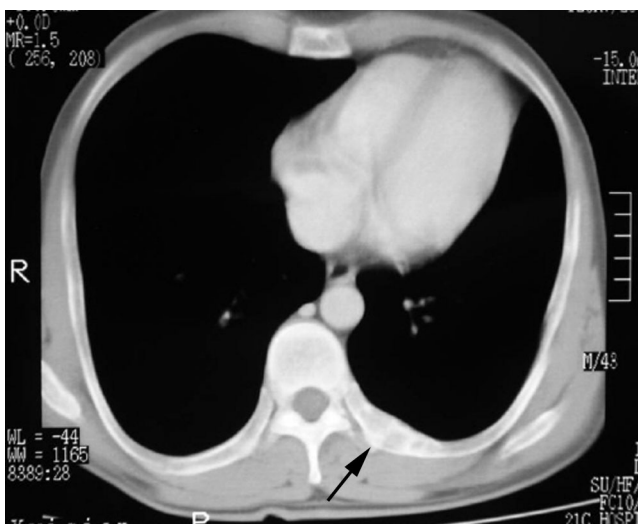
Chest CT scan shows expansile osteolytic lesion without cortical destruction or periosteal reaction in left 7th rib (arrow).
